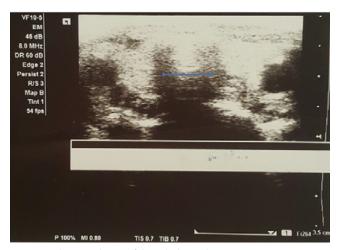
Ultrasound view of the subglottic diameter Note: The blue arrow (\longleftrightarrow) indicates the dimension of the subglottic diameter
